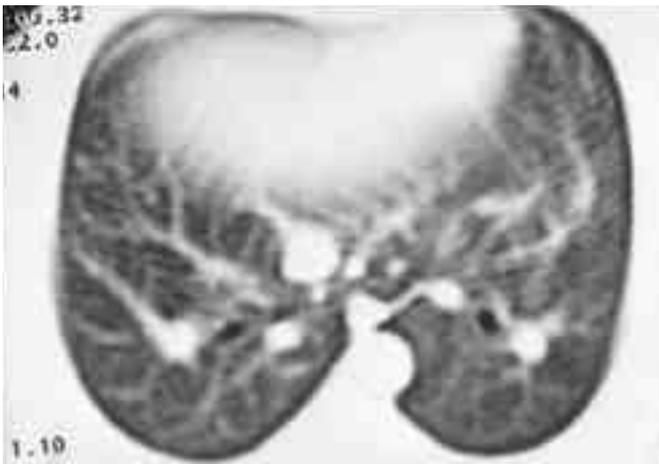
Immediate CT and pathologic findings after embolization
